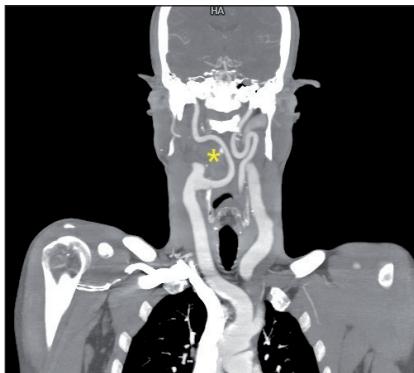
Angio-MRI: Coronal reconstruction showing no retropharyngeal aneurysm (*).
